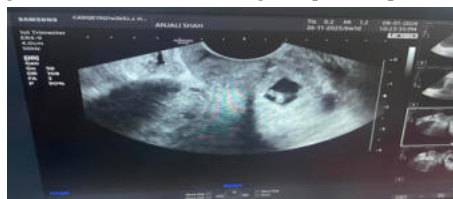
Ultrasound showing cervical ectopic pregnancy.
